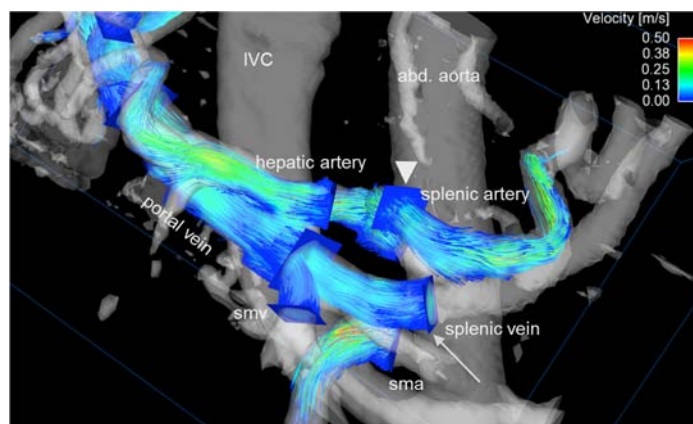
Particle traces from a contrast-enhanced 4D Flow MRI of a 62-year-old female with cirrhosis and portal hypertension demonstrating the positioning of emitter planes in the splenic artery (arrowhead) and splenic vein (arrow).
